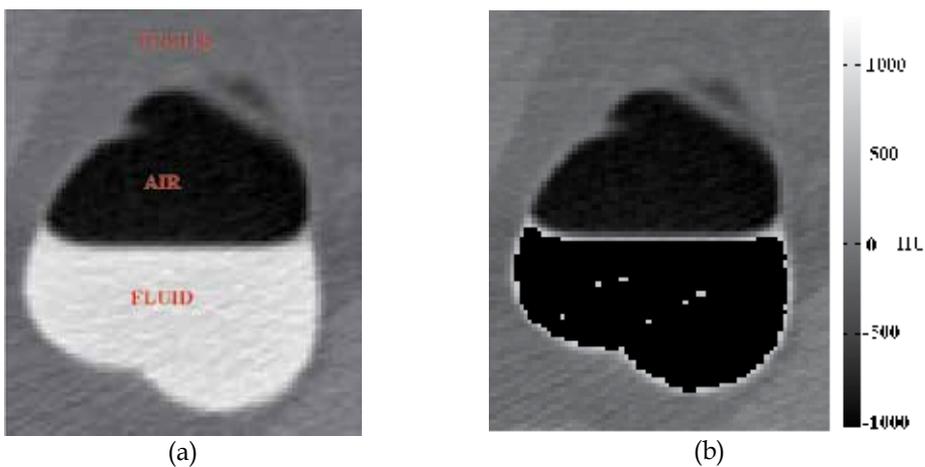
2D slices of: a) 3D CT data; b) 3D CT data after classical thresholding operation
